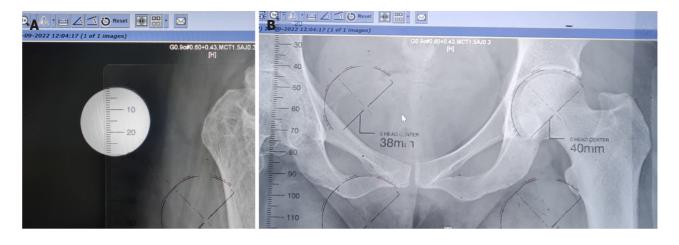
Templating with digital X-rays using a computer. A: 3-cm diameter metal ball is strapped to the thigh for X-ray. The scale on the template is matched to 3 cm by using the zooming feature (zoom in or zoom out); B: Match the size of the acetabulum to the correct size. Care is taken to assess the optimal size with respect to the teardrop, lateral edge, and acetabular floor. Arrows indicating the ball size matched and the template matching acetabular component size.
